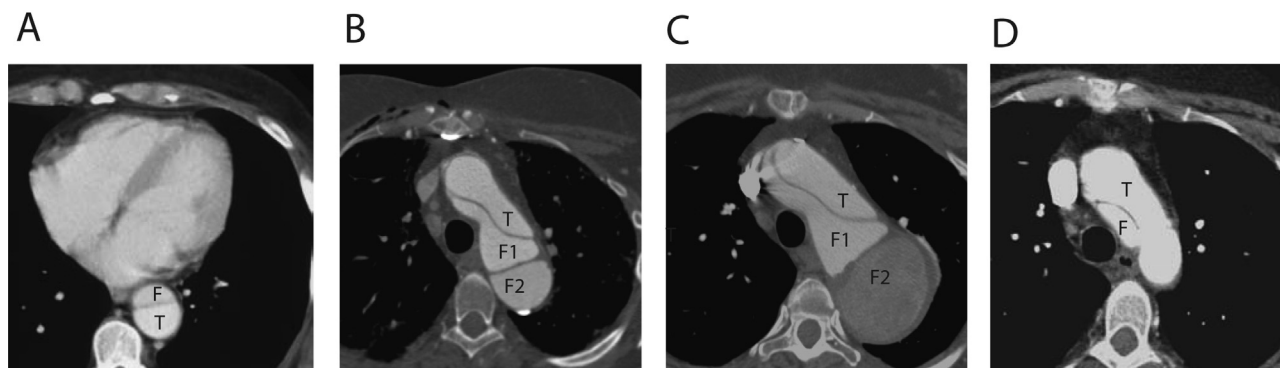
Computed tomography angiography images of the evolving aortic dissection anatomy in the patient from case 1. (A) At age 36, a single dissection flap separating the true (T) and false (F) lumens in a descending aorta that is only mildly dilated. (B) At age 46, an image taken when the patient presented with recurrent symptoms, which now demonstrates 2 dissection flaps that separate the true lumen (T), original false lumen (F1), and second false lumen (F2). (C) At age 47, a similar flap configuration is present but the F2 lumen has expanded, resulting in a large thoracoabdominal aneurysm. (D) One year after surgical repair, an intimal flap persists in the aortic arch.
